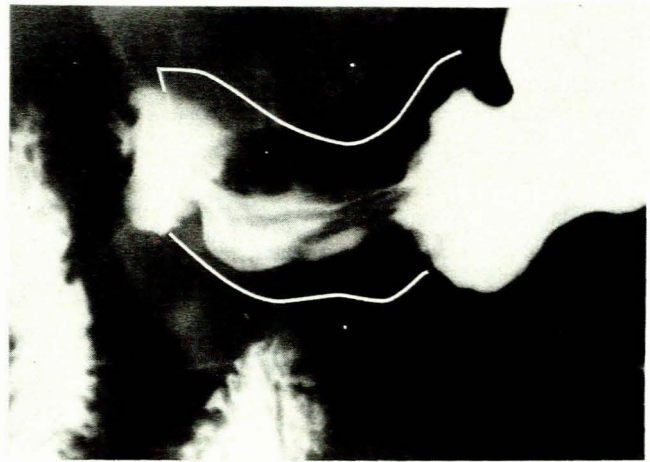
Radiograph showing living anatomy. Two fine, flexible metal wires (retouched) are attached to the serosal surfaces of the greater and lesser curvatures. The space between the wires and the barium in the lumen indicates the cylindrical muscular contraction.
